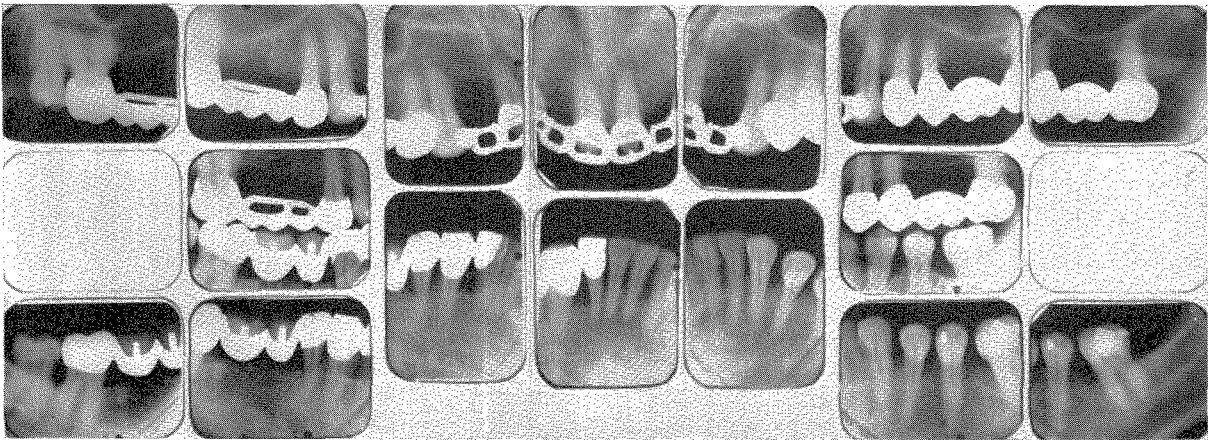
Roentgenograms taken in February, 1947.
